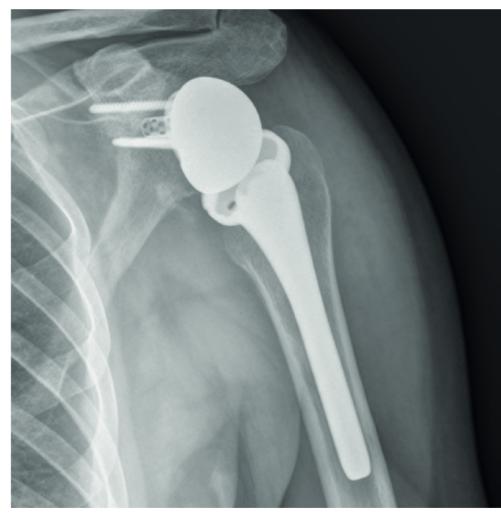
Post-operative x-rays examination
